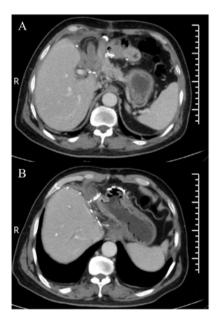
Postoperative CT scan. CT results of the patient's follow-up 4 months after surgery showed that the tumor at the (A) common bile duct and (B) left hepatic duct had been removed. The white arrow next to the liver shows the silver clip; red arrow shows the stapler used during the operation.
